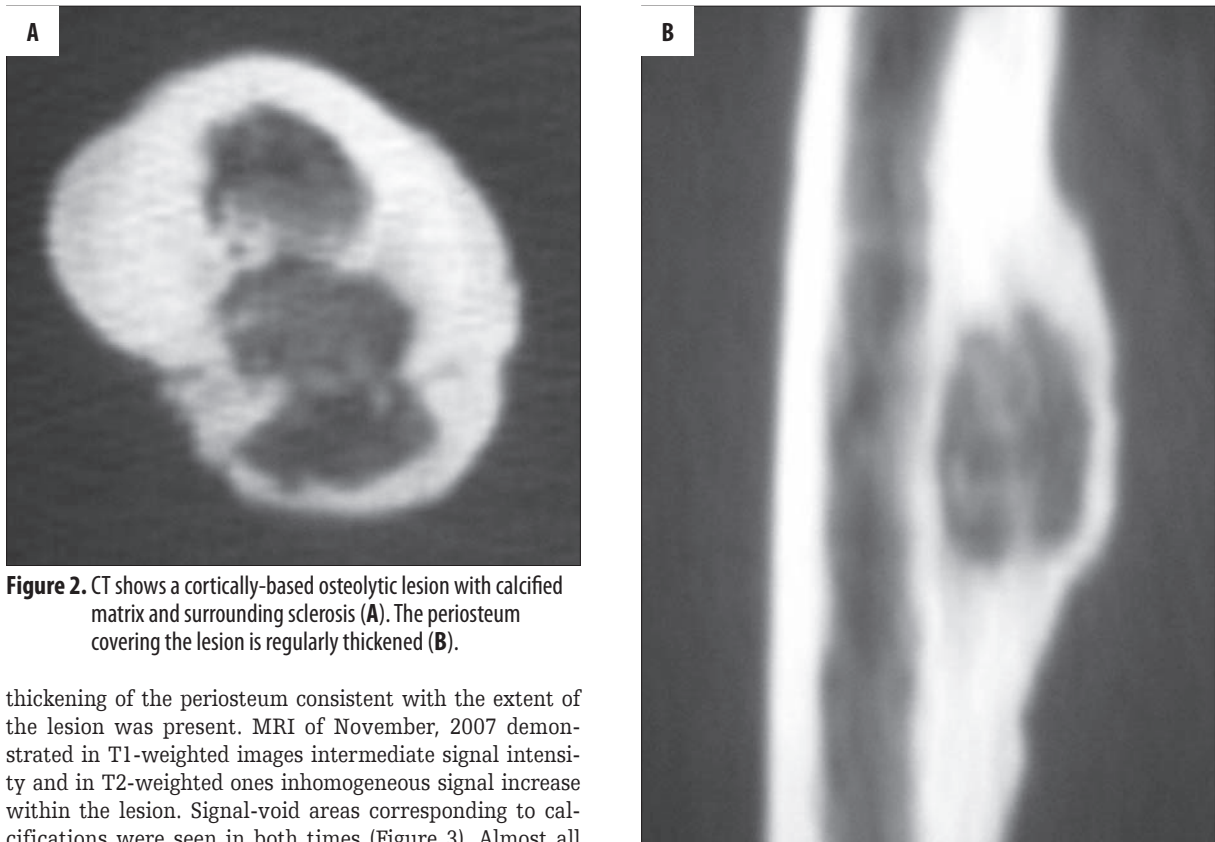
CT shows a cortically-based osteolytic lesion with calcified matrix and surrounding sclerosis (A). The periosteum covering the lesion is regularly thickened (B).
